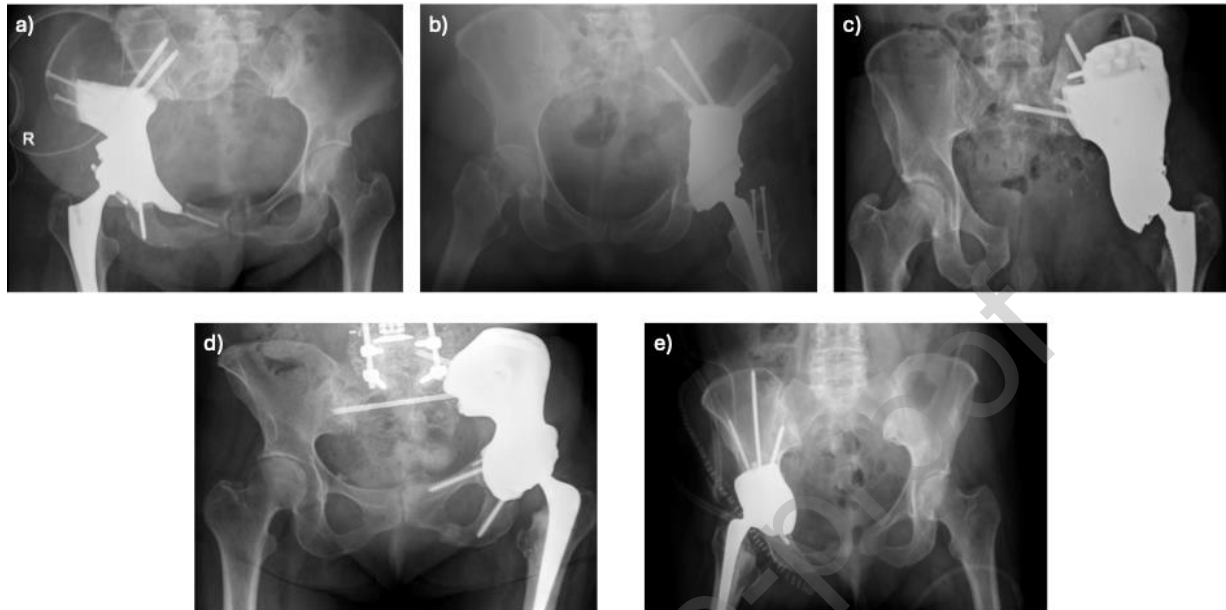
Post-operative X-Ray of Case 1 (a), Case 2 (b), Case 3 (c), Case 4 (d) and Case 5 (e) showing successful implantation of custom prosthesis after resection using a PSI that references the acetabulum.
